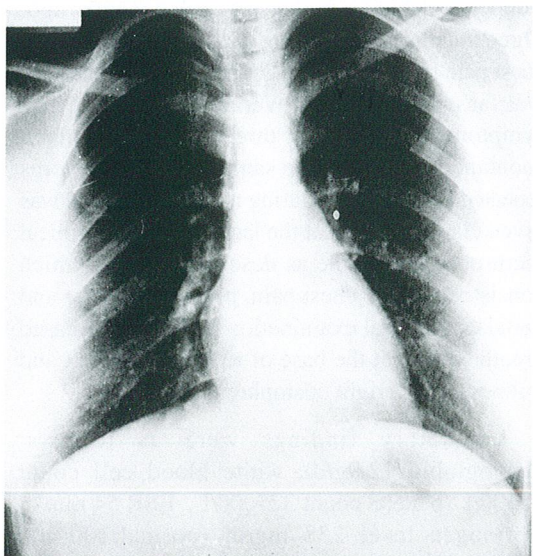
Chest X-ray on the fourth day of colchicine therapy.
